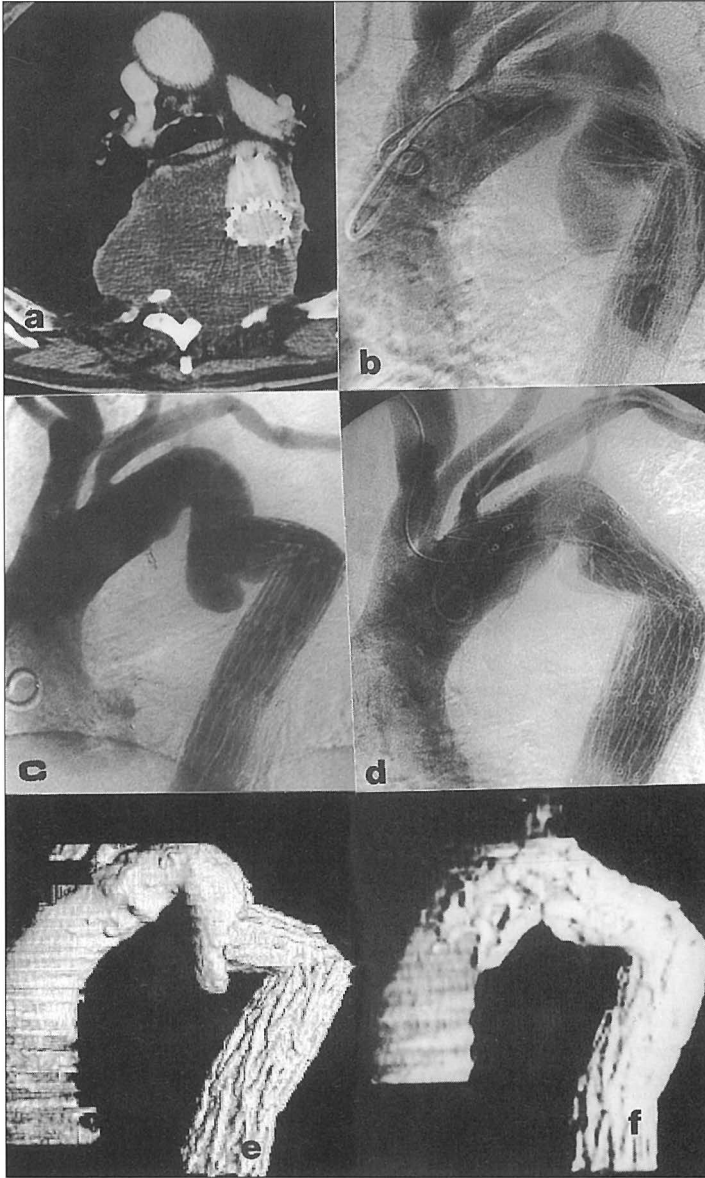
Late complication of endoprosthesis treatment in thoracic aorta and its cure. A) Transversal slice on spiral CTA shows bending of endoprosthesis with leakage into big aneurysm, which eroded thoracic spine segments. B) DSA of thoracic aorta in LAO shows movement and bending of prosthesis towards aneurysm, widened aorta over endoprosthesis and leakage to aneurysm. C) 3D reconstruction of spiral CTA in LAO projection confirms angiography. D) Introduction of delivery system with endoprosthesis over bending and curves as also highly positioned aortic arch towards subclavian artery, after which there is attachment site of new endoprosthesis. It is achieved with guide-wire, which is pulled through brachiocephalic and axillary artery out and additionally firmed. E) New endoprosthesis reaches up to left subclavian artery orifice and down to straight part of pre-existing endoprosthesis (marks shaped as no.8). Bending of endoprosthesis is sufficiently corrected, leakage is not obtained any more. F) Spiral-CTA in 3D reproduction shows good position of endoprosthesis, correction of bending and no leakage.
